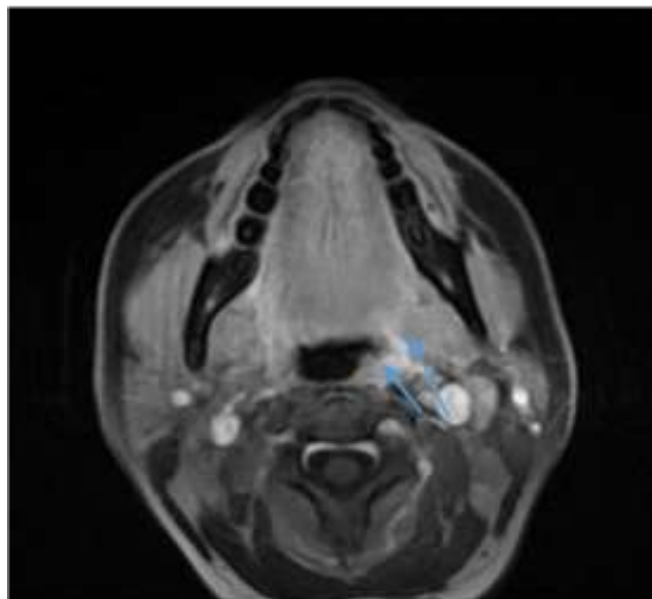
MRI in axial sections with sequences T2 turbo-spin-echo sequence with fat saturation. Showing a well-circumscribed, lobulated budding mass, limited to the left palatine tonsil (arrow), massively gaining contrast during injection times, without invasion of the adjacent muscle structures
